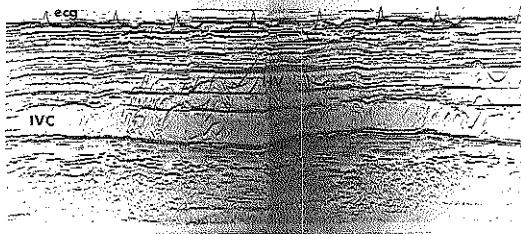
M*-mode contrast inferior vena cava (IVC) echocardiogram showing a "random" pattern of contrast appearance in the IVC and hepatic vein (HV), with retrograde flow (upward-sloping contrast lines) occurring with no fixed relation to the cardiac cycle. This is the most common false-positive pattern of contrast appearance in patients with atrial fibrillation.
